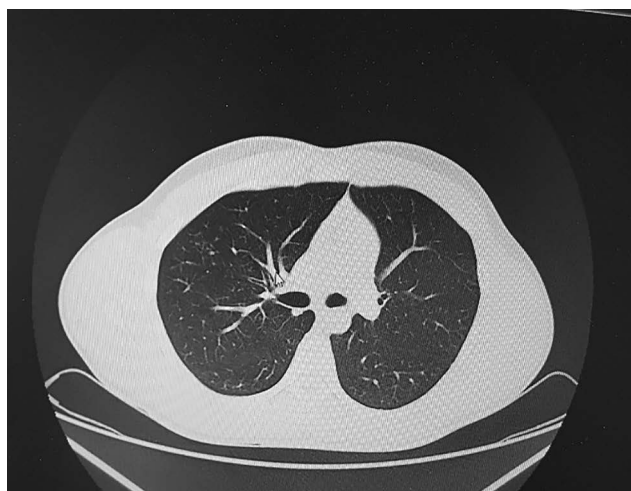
Control CT in the 6th month of treatment (final CT) – normal image of the lung and the mediastinal structures. There are no CT findings for focal and nodular lesions in the lung.
